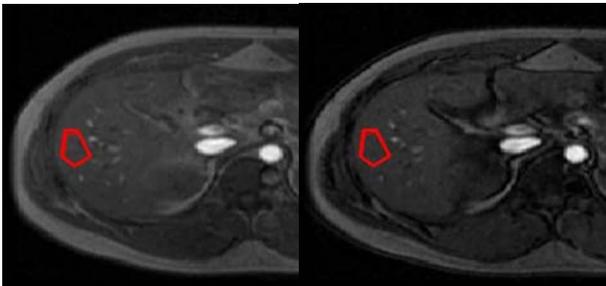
MRI image pair with selected ROI. Left: In-phase image, Right: Out-of-phase
